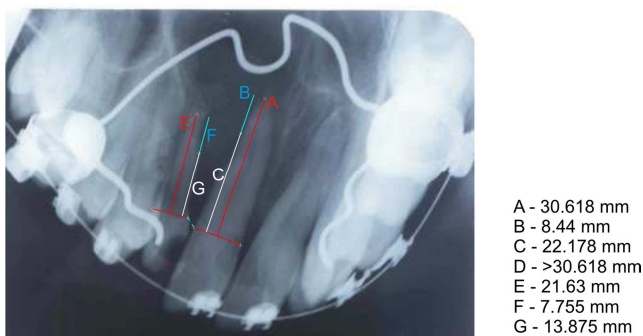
Linear measurements recorded on Pre operative Occlusal radiographs using CorelDraw suite 15.
